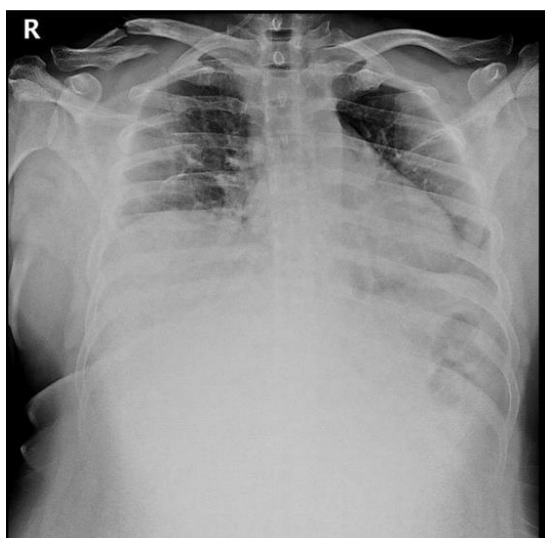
Posteroanterior Thoracic X-ray Before Surgery
